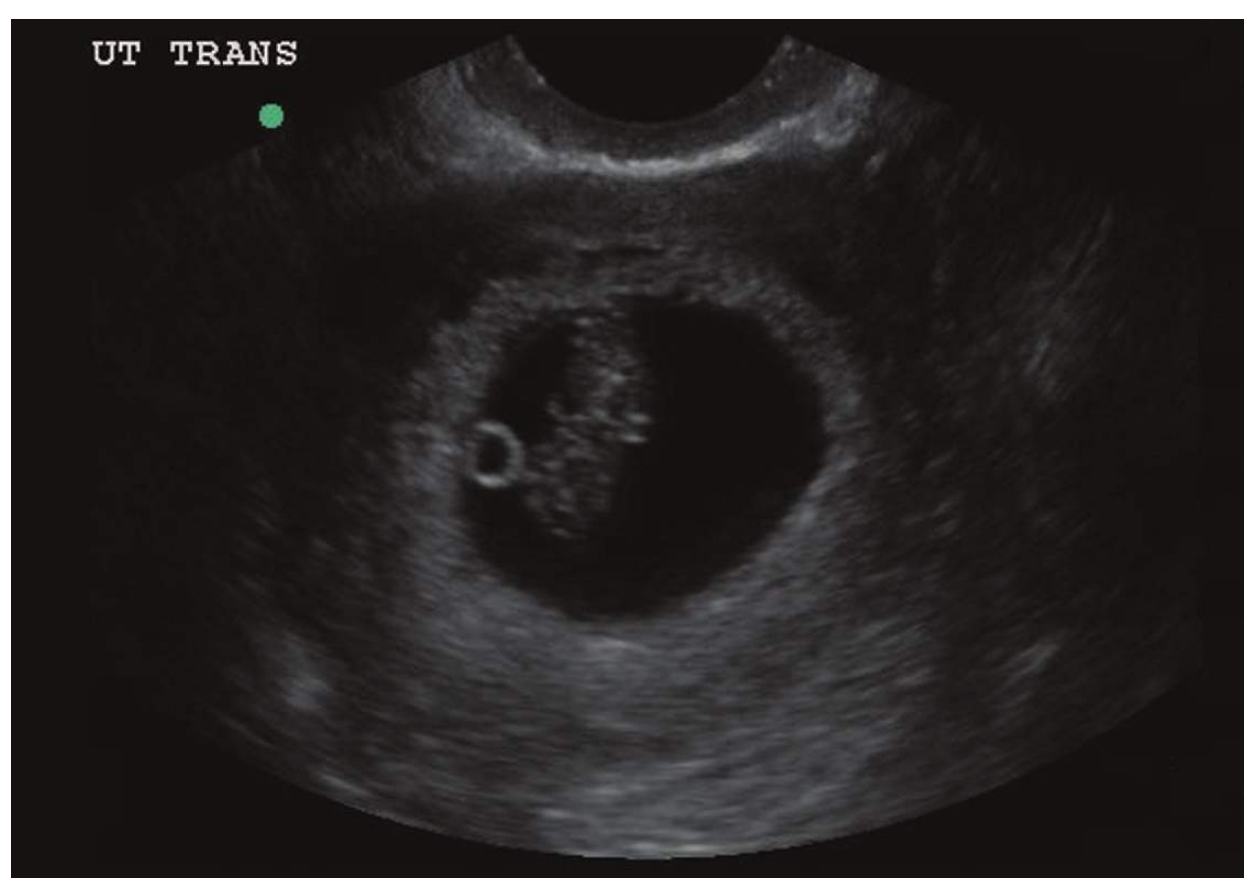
■ Intrauterine Fetal Pole. Ultrasound image of an intrauterine pregnancy with a fetal pole seen adjacent to a yolk sac. (Photo contributor: Lauren Oliveira, DO.)
